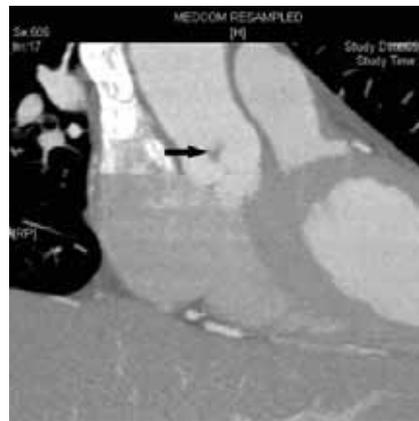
64-slice cardiac computed tomography long-axis maximum intensity projection showing the same aortic valve filling defect.
